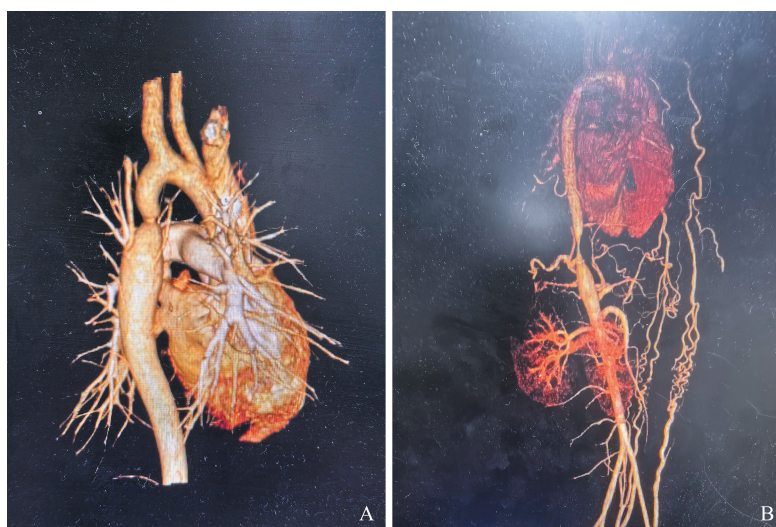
CT 示降主动脉局部狭窄(A)及胸主动脉管状缩窄(B)
